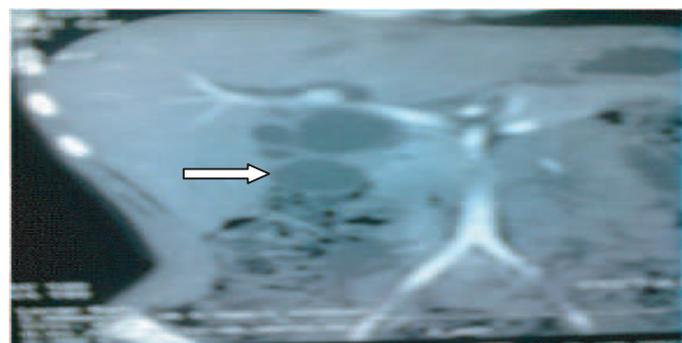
CT Scan- Choldochal cyst (Case-2).
